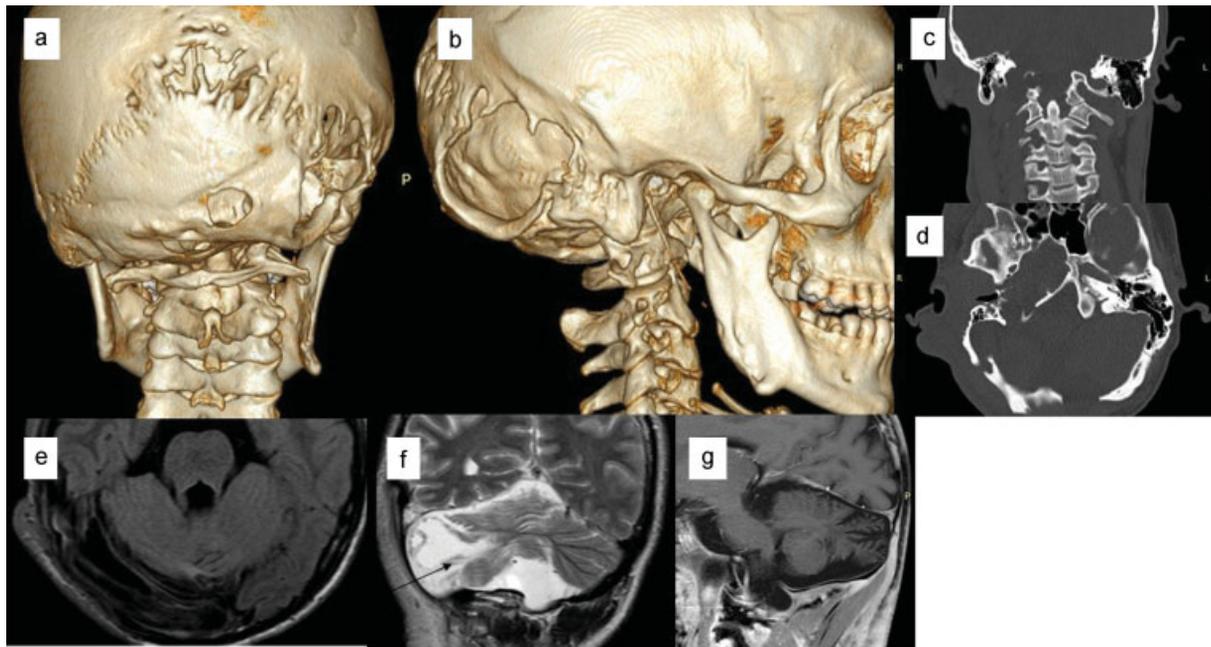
Imaging of cranium and brain. Computed tomographies (CTs) of the patient's skull with three-dimensional reconstruction of skull surface. (a) Occipital view of the skull discloses dehiscence of right lambdoid suture with some bone bridges. Further defects of occipital bone are located caudally and not associated with the suture. There are further skeletal findings on the PNF-affected side: dysplasia of the upper vertebrae, extension of the right mandibular angle in caudal direction, and small volume of mastoid. (b) Lateral view on the bone surfaces shows deformation of glenoid fossa, and thin styloid ligament. (c) Coronal view discloses the asymmetrical pneumatization of mastoid and associated concavity of the calvaria. Soft-tissue thickness of the scalp is clearly greater on the right side. (d) Multiple occipital skull defects are associated with soft-tissue mass covering, in this CT sectional image, the entire right side of the skull. Note distance of pinna to the bone. (e–g) Magnetic resonance images (MRIs) of calvarial extension of plexiform neurofibroma and associated malformations of the brain. (e) Axial section of cerebellum region on T1-weighted MRI shows cyst-like extension of subarachnoidal space. (f) The right cerebellar lobe shows hyperintense stimulation preferentially in the gyri on T2-weighted coronal MRI. (g) Sagittal T1-weighted MRI identifies cyst-like space occupying lesion surrounding circularly the cerebellum.
